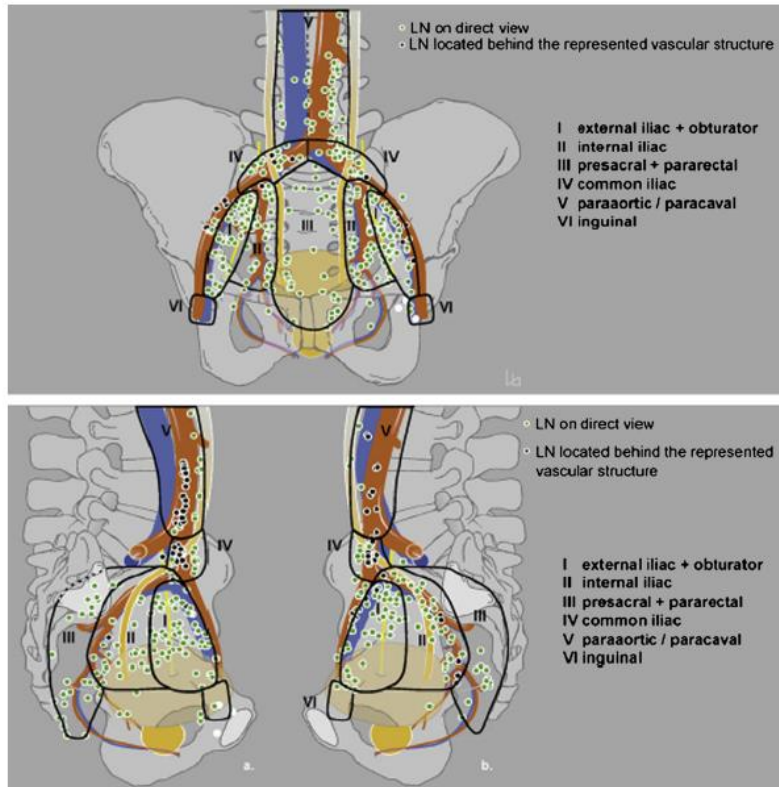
Anteroposterior (A) and lateral (B) lymphatic drainage maps based on intraprostatic injections of technetium followed by single photon emission tomography (SPECT) combined with either computed tomography or magnetic resonance imaging fusion confirmed by surgery. Lymph nodes were color coded and subsequently transferred into a template projection of the pelvis according to their relation with vascular structures. From Mattei *et al.* (45).
